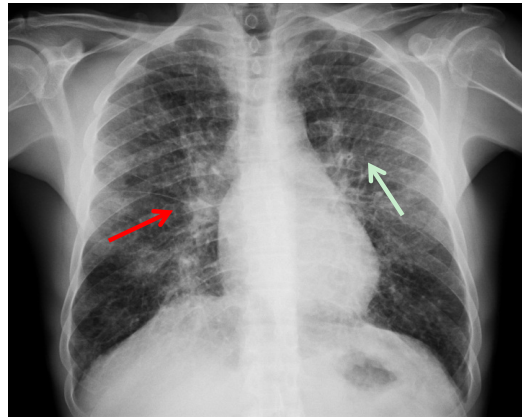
Chest X-ray showing diffuse interstitial infiltrate of reticular aspect (with the arrow), with thickening of the right horizontal fissure (red arrow).
